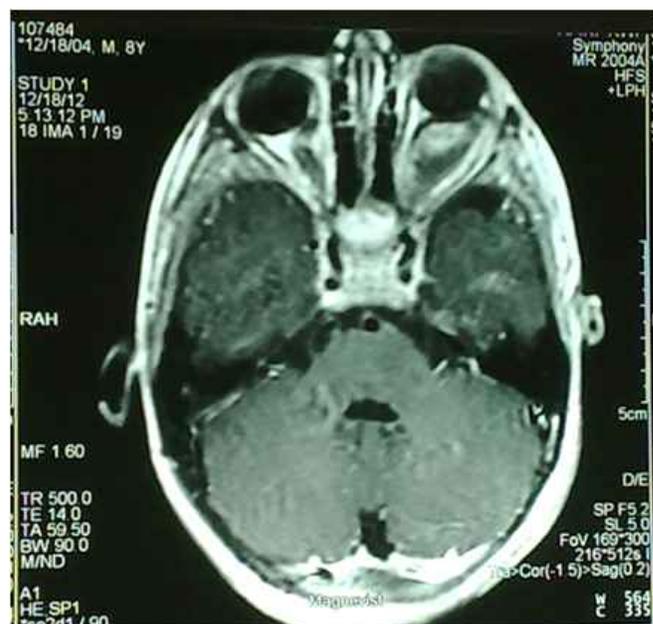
Axial T1-weighted MRI showing the kinking of the right optic nerve and the fusiform left optic glioma.
